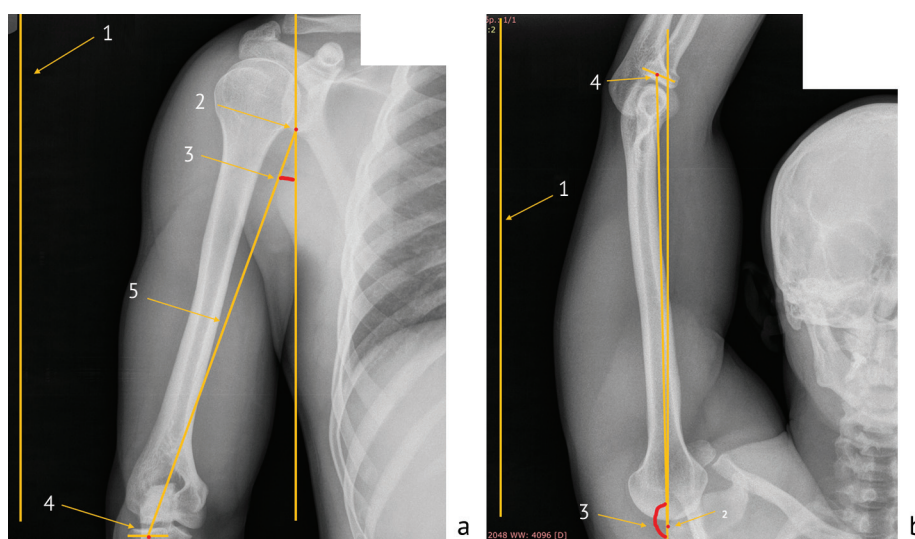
Radiographs showing the shoulder abduction at: (a) zero position; (b) maximum abduction (1: vertical (template); 2: lower pole of the glenoid, through which the vertical (template) to be drawn; 3: abduction angle; 4: center of the radial head; 5: the line drawn through the lower pole of the glenoid and the center of the radial head)
